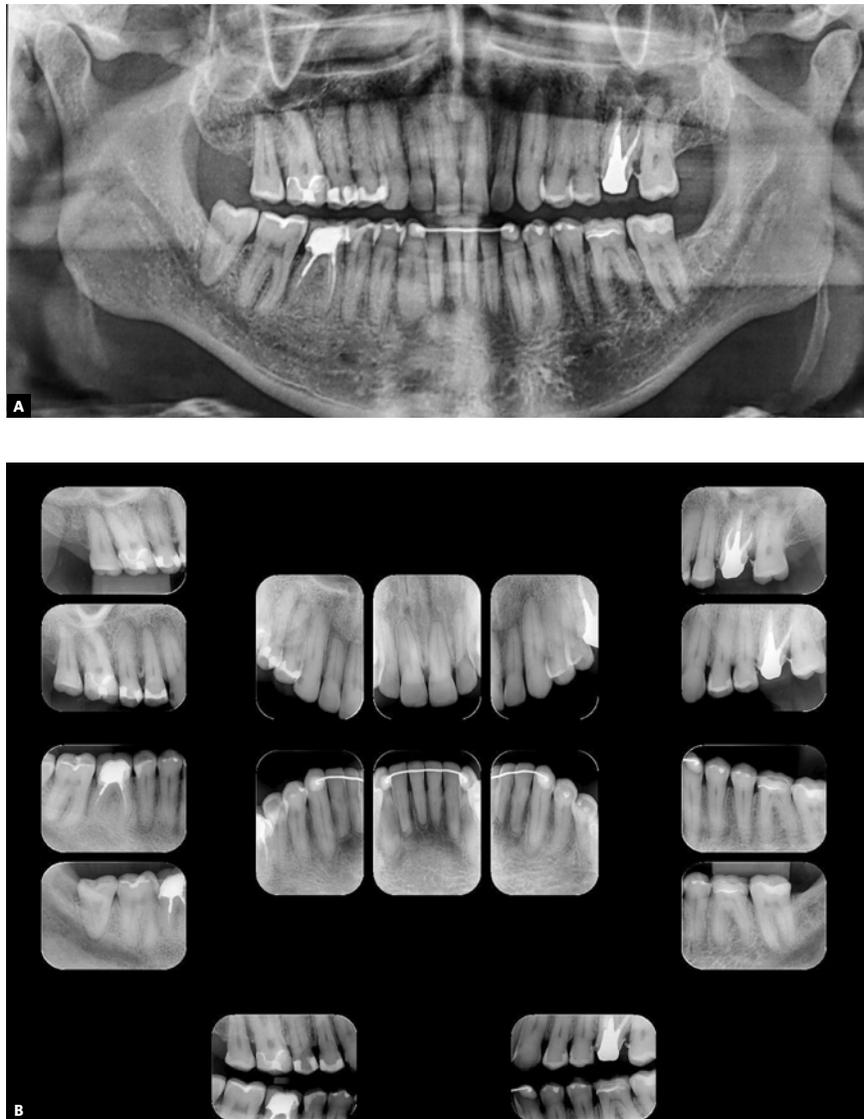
Final panoramic (A) and periapical (B) radiographs.
